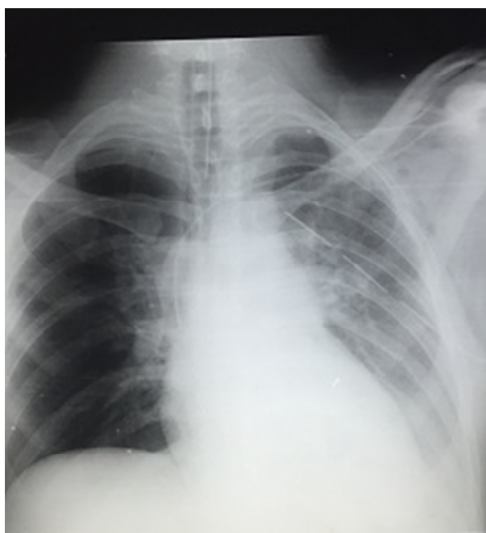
Chest X-ray showing left chest tube and left pleural effusion.
